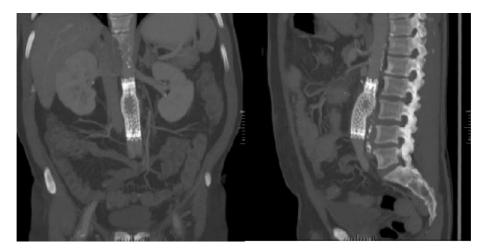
Computed tomography scans showing the Gore TAG stent-graft in place 12 days after surgical closure of the aortoduodenal fistula.
